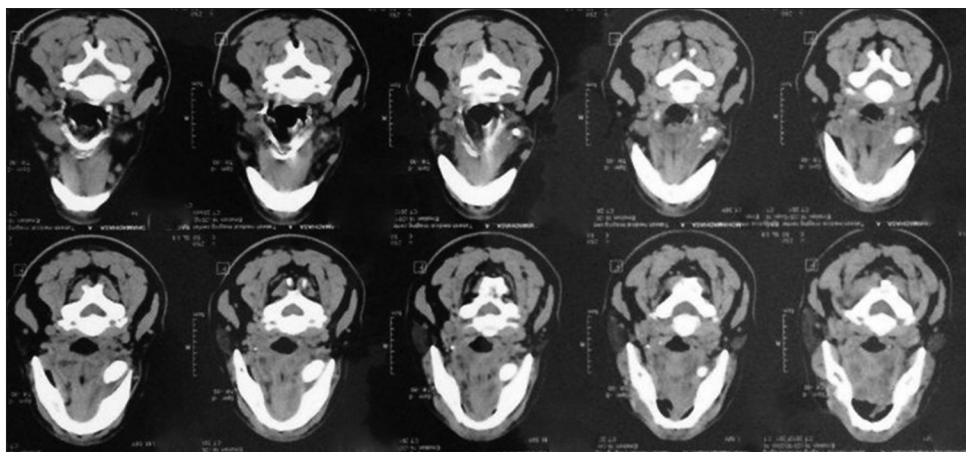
Sagittal view of spiral CT of sialolithiasis
